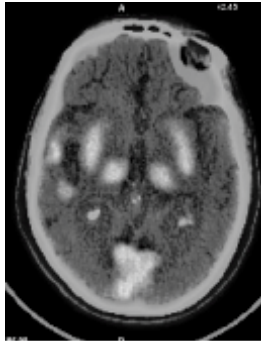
An advanced case of Alzheimer's disease : FDG PET/CT scan shows bilateral temporo-parietal and frontal hypometabolism with sparing of occipital cortices.
